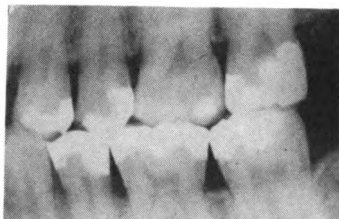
Posterior bitewing roentgenogram.
